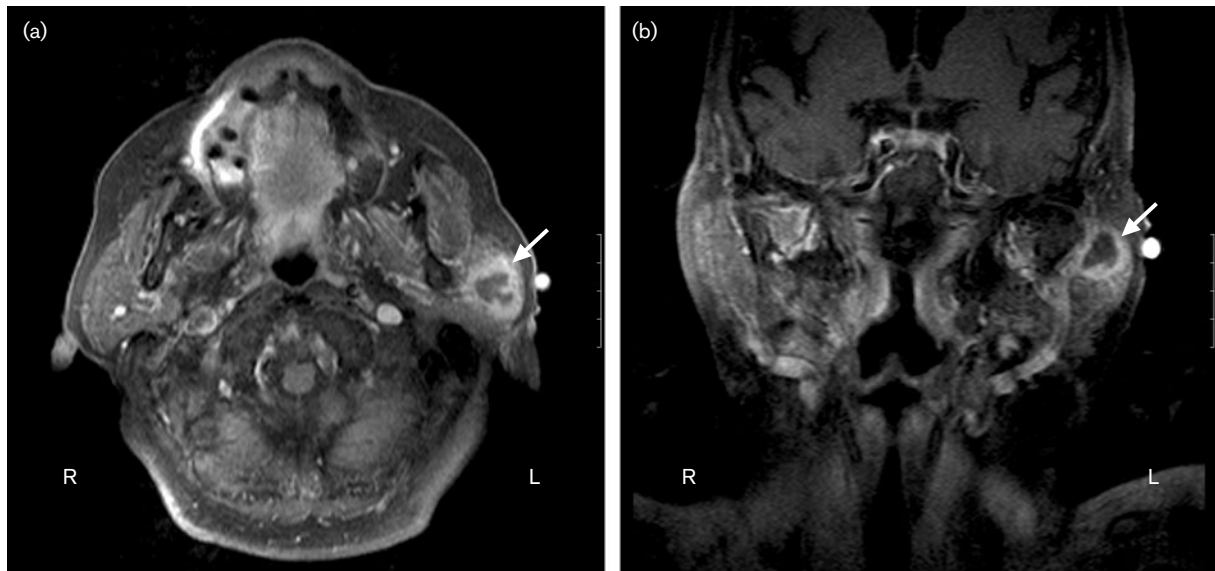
MRI scan of the head and neck region of the patient after intravenous application of gadolinium-diethylenetriamine-pentaacetic acid. The tumour-like lesion is located in the upper region of the left parotid gland and appears to have a central necrosis. (a) Horizontal section; (b) longitudinal section.
